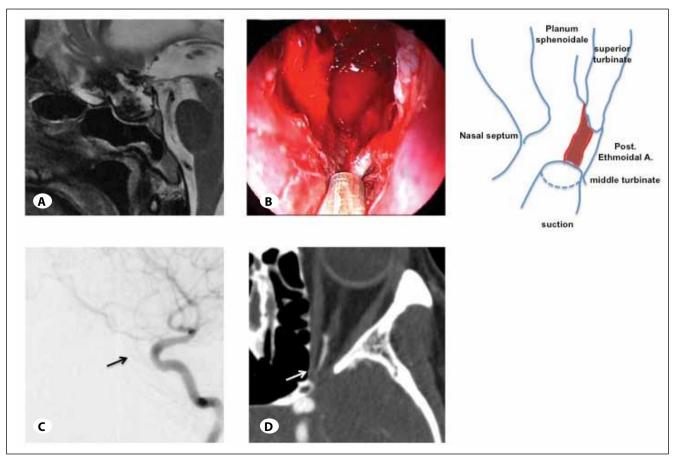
A) Sagittal section view of Gd-enhanced T1-weighted MRI showing a calcified craniopharyngioma located at the intrasellar and suprasellar region. B) Intraoperative endoscopic view showing a PEA on the left side passing along the supreme turbinate. Active bleeding was controlled under suction (left). Scheme of the intraoperative endoscopic view (right). C) Lateral view of internal carotid artery angiography showed branching of the PEA from the ophthalmic artery and distributing to the posterior ethmoidal sinus.
